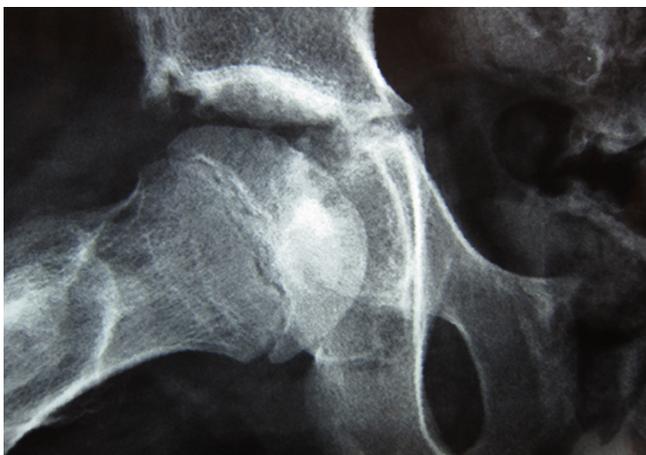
The X-ray shows that after six years, the spherical shape of the femoral head has been preserved.
